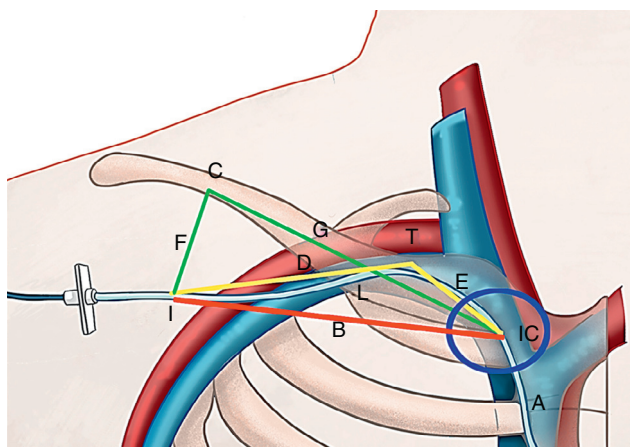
The I-T-IC, I-C-IC, and I-IC distances were measured after ultrasound-guided insertion of the right subclavian venous cannulation catheter. The blue circle indicates the ipsilateral clavicular notch (IC). The actual total catheter insertion length (L + A) was calculated by adding (i) the distance between the needle insertion point and the ipsilateral clavicular notch (this distance is designated as L) to (ii) the distance between the ipsilateral clavicular notch and the catheter tip (this distance is designated as A). The I-T-IC distance is the distance from the needle insertion point to the ipsilateral clavicular notch via the top of the subclavian vein (i.e., distance D + distance E) that is indicated by the yellow line. The I-C-IC distance is the distance from the needle insertion point to the ipsilateral clavicular notch via the clavicle (i.e., distance F + distance G) that is indicated by the green line. The I-IC distance is indicated by B and the red line, and is the direct distance from the needle insertion point to the ipsilateral clavicular notch.
